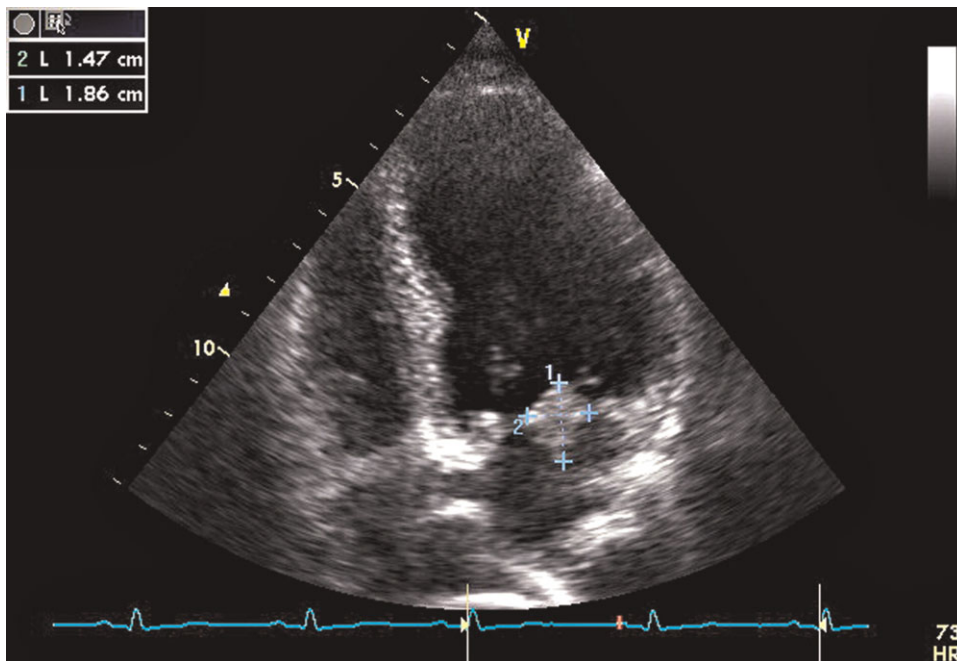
Transthoracic apical four-chamber view showing a rounded homogeneous mass located at the level of the mitral valve.
